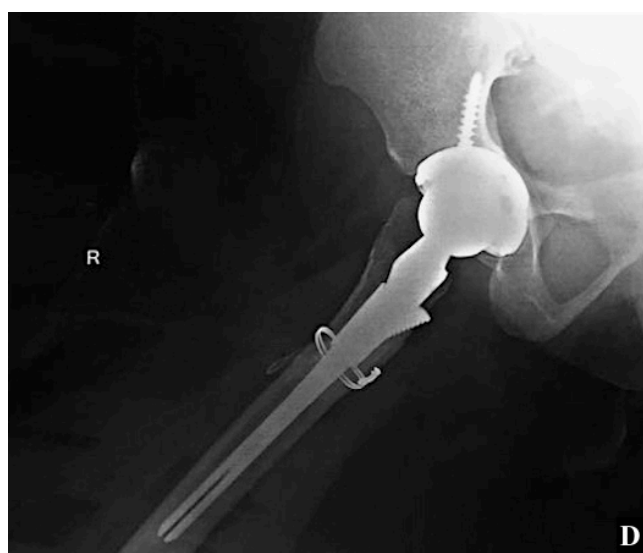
Follow up X-ray of same hip in lateral view showing complete union at the osteotomy site.
